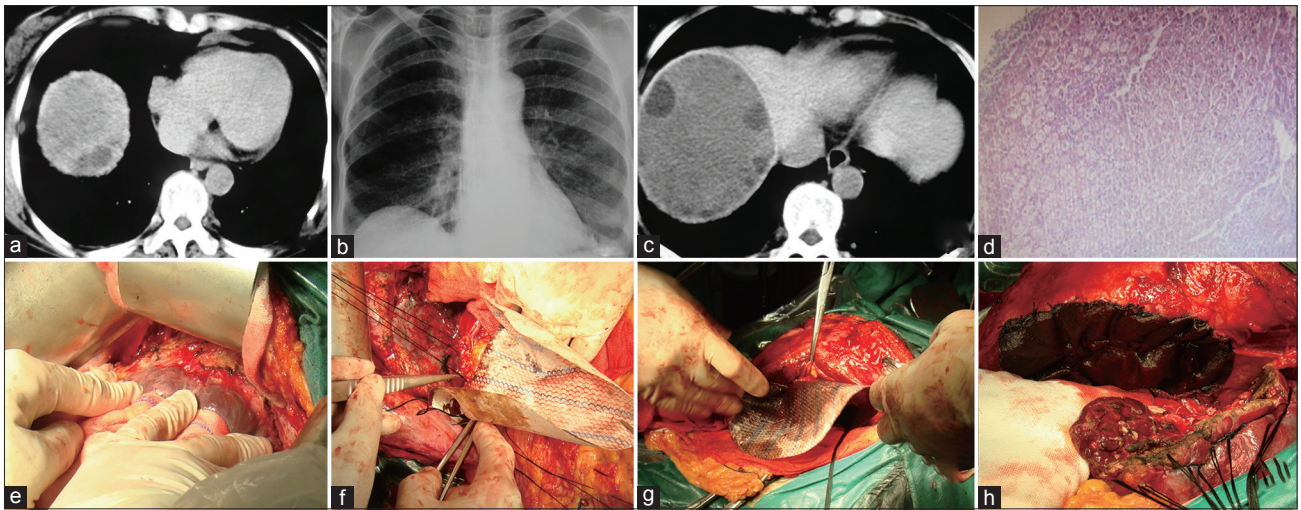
(a and c) There was a cystic neoplasm in the right posterior of the liver with a size about 10 cm x 7cm x 7cm; (b) From the X-ray we can see the right side of diaphragm raised obviously; (d) The pathologic diagnosis was hepatic hydatid disease; (e) The hydatid has invaded the right diaphragm, there is no clearance can be found between the capsule and diaphragm; (f) After resected the right lobe of liver, there is a big hole in the diaphragm, the lung can be seen through the hole; (g-h) After the right lobe resection, the patch was sutured to the defect diaphragm. Also, we can see only left lobe of liver in figure h.
